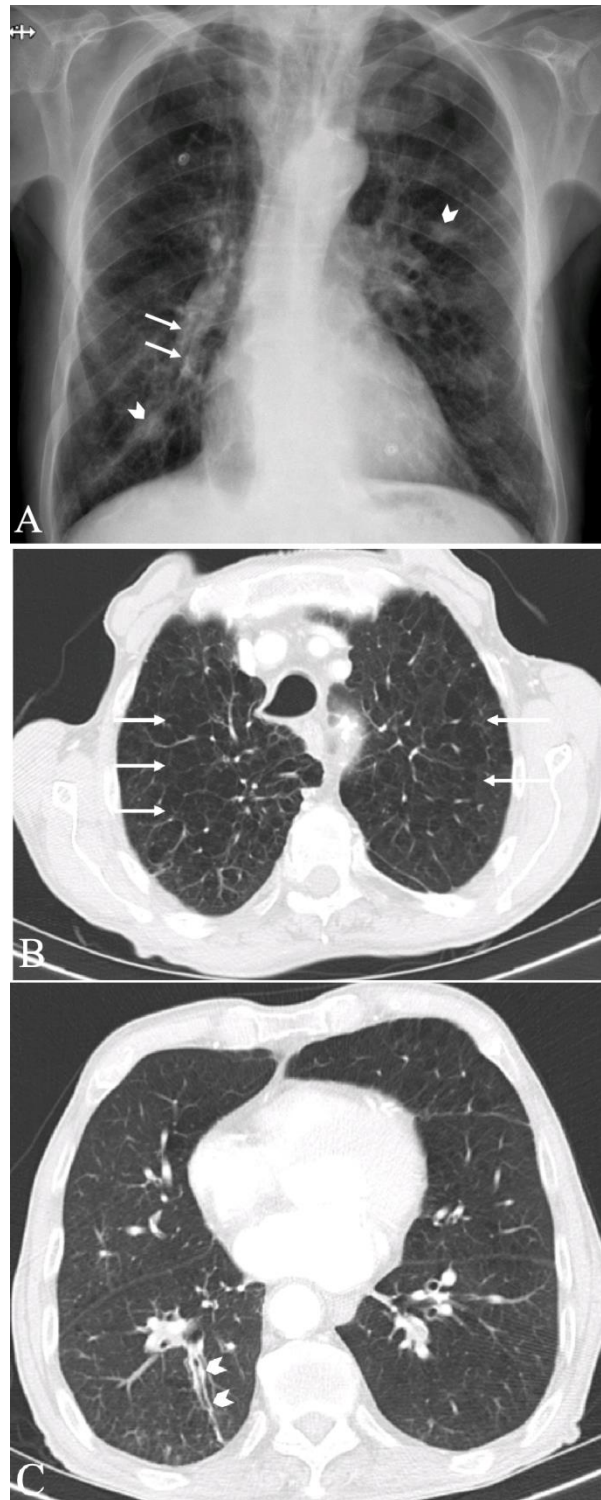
A 71-year-old male heavy-smoker with a normal PFT. PA chest X-ray shows bronchial wall thickening (arrows, A) and nodular opacities (arrow heads, A). Axial contrast-enhanced thorax CT images show centrilobular emphysema dominantly in the upper lobes of the bilateral lungs (arrows, B) and bronchial wall thickening (arrow heads, C).
